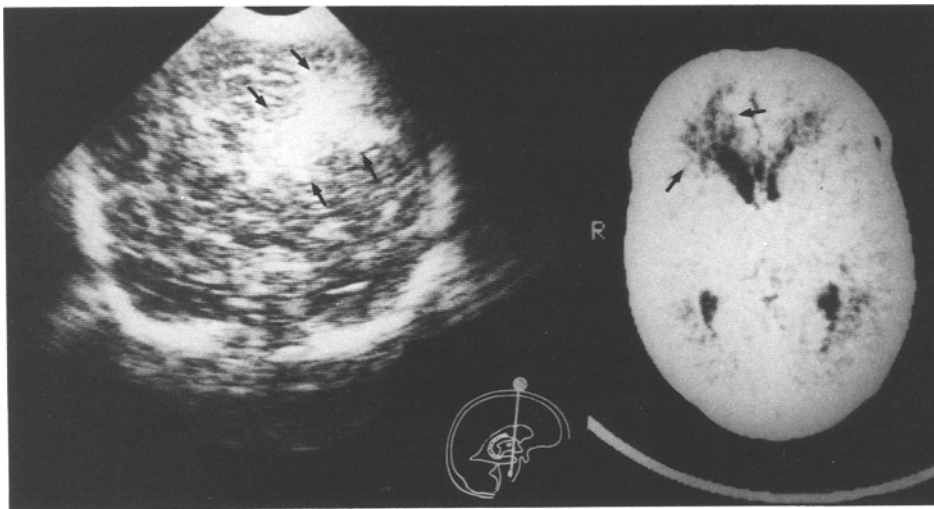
Patient 1.* Ultrasound on day 2 (*left*): increased echogenicity of the right precentral area. Computerized tomogram on day 14 (*right*): right frontal hypodense area
